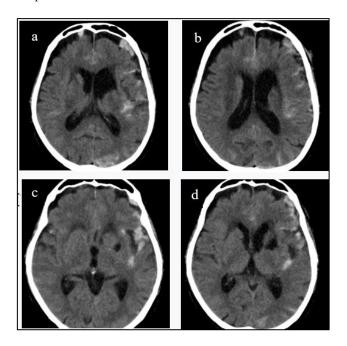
(A-D): Non-contrast computer tomography (CT) brain showing abnormal hyperdense lesions with focal intraparenchymal oedema in the frontal, parietal, occipital regions. The cortical sulci and gyrus appear dilated. The ventricular system and cisterns appear dilated with hydrocephalus and cerebral atrophy.
